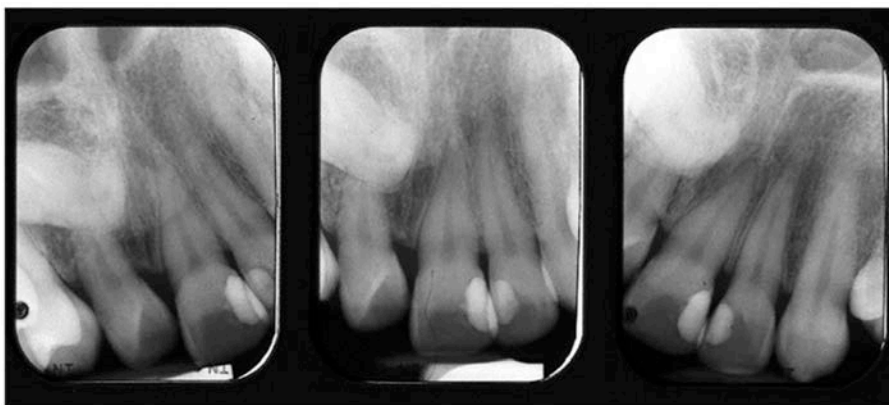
Periapical radiographs of distoangular horizontal impaction of maxillary central incisor #8.
